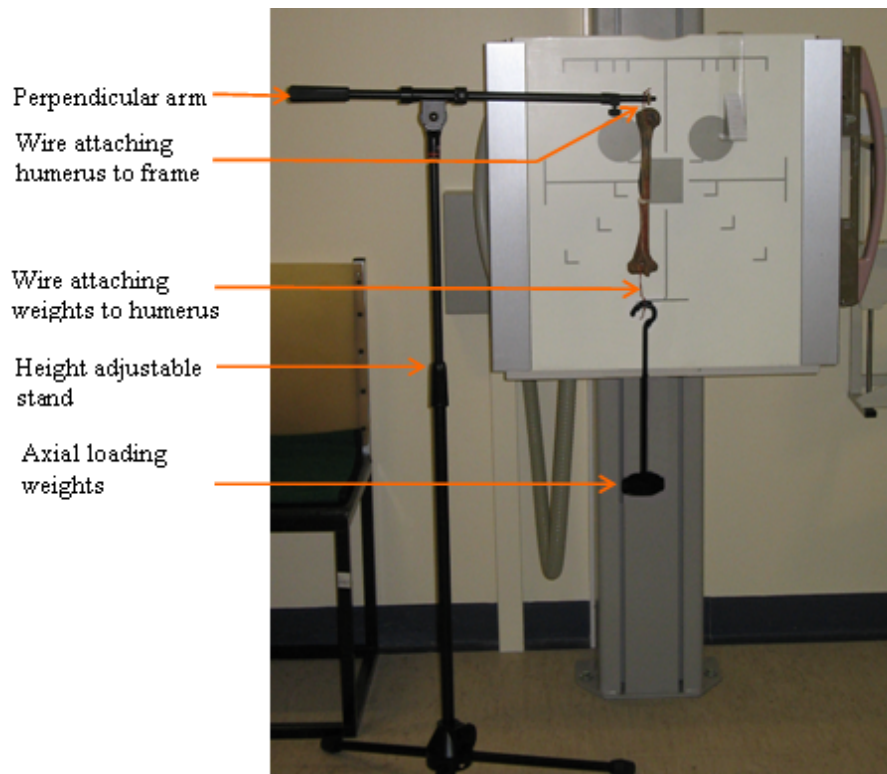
The humeral fracture X-ray set up.
